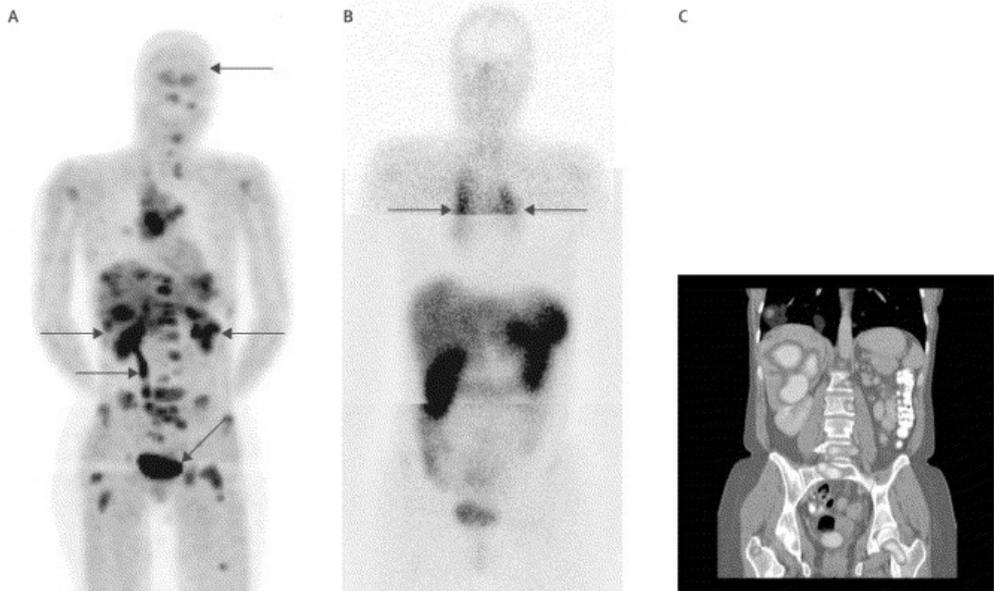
Full-color in appendix. Imaging of a patient with carcinoid disease and metastases in the bone, mediastinum, liver, and abdomen. (A) ^{18}F -DOPA PET imaging. Red arrows indicate areas with physiological ^{18}F -DOPA uptake (striatum, kidneys, ureter, bladder), whereas all other black spots are tumour lesions. (B) Planar SRS imaging. Arrows indicate mediastinal tumour lesions. (C) CT-PET fusion imaging. Coloured areas indicate tumour lesions. In this patient, both planar and SPECT SRS missed most lesions found with ^{18}F -DOPA PET imaging. Abdominal and femoral lesions were not recorded on CT.
